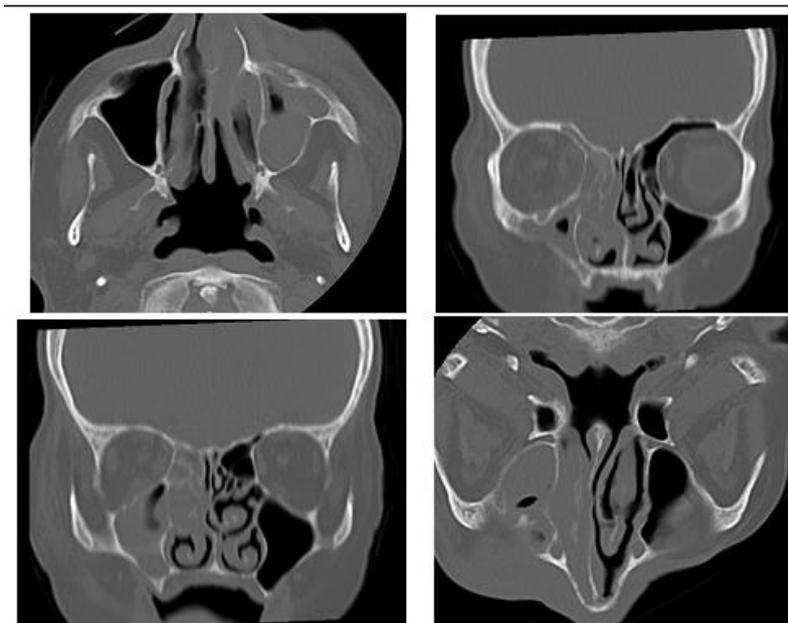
Computed tomography maxillofacial without contrast showing opacity in the frontal and right ethmoid sinuses, mucosal thickening and remodeling in the right sphenoid, ethmoid, frontal and maxillary sinus, and widening and obliteration of the right osteomeatal complex.
